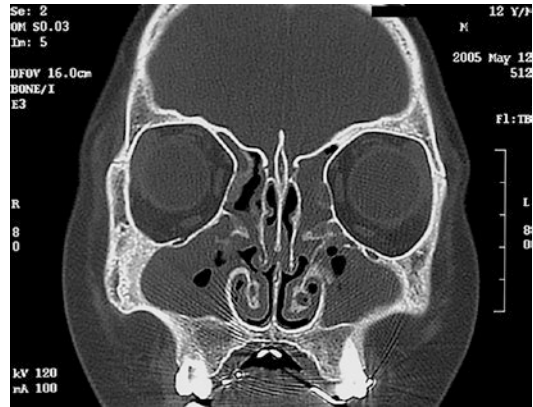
Coronal paranasal sinus computed tomography (CT) in a 12-year-old boy with recurrent chronic rhinosinusitis who underwent limited functional endoscopic sinus surgery. Severe synechiae in the middle meatus and purulent discharge were visible with nasal endoscopy 1 year later. Opacification in the ethmoid and maxillary sinuses, with bone hyperplasia are seen
